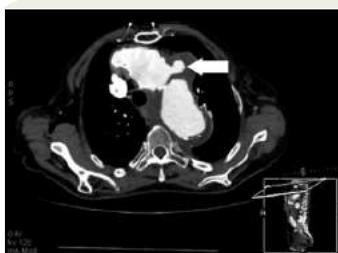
CT scan showing the ulcer of the ascending aorta.<sup>1</sup>
